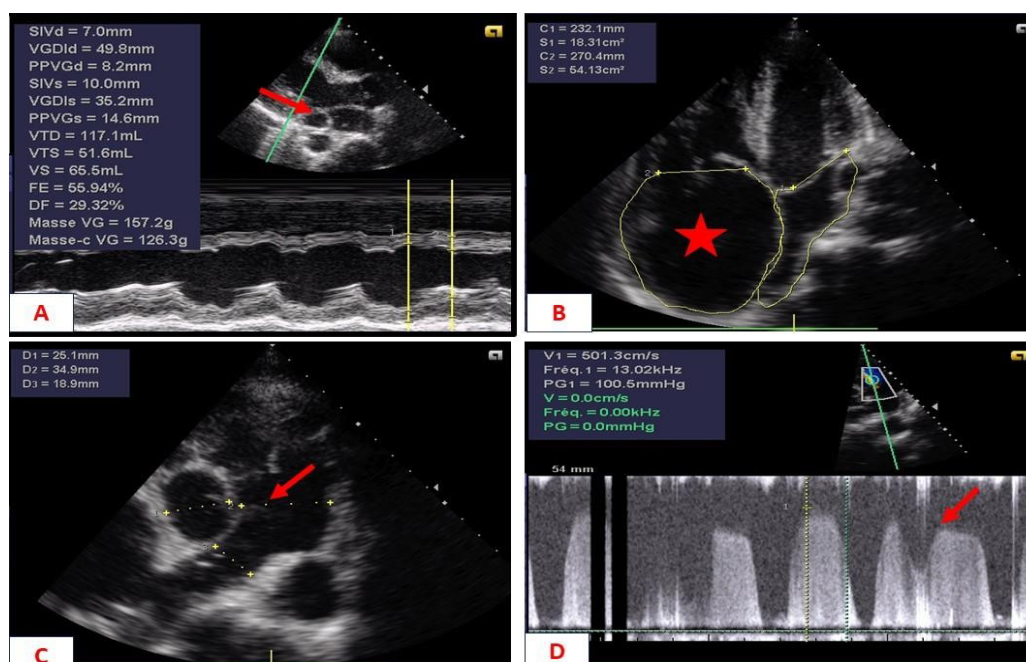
Transthoracic Doppler echocardiogram showing
